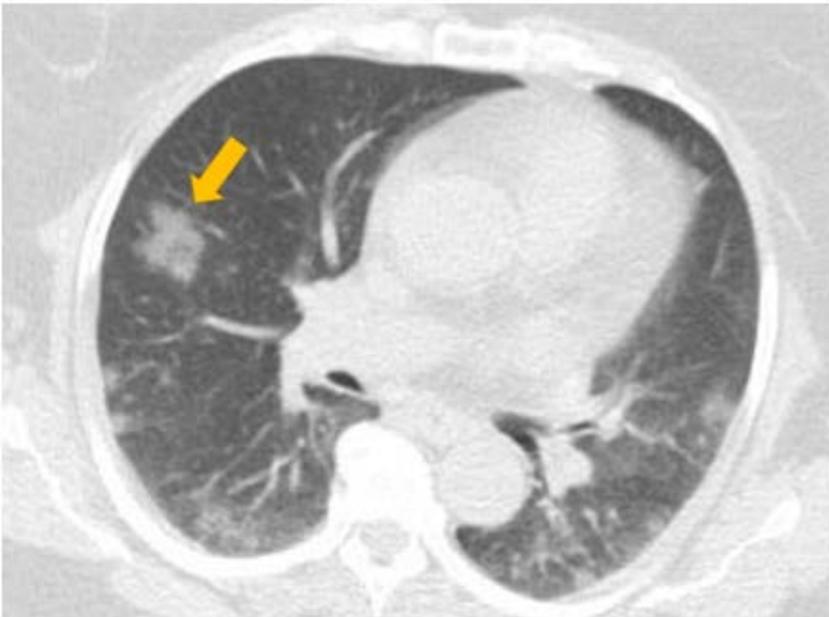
Ground-glass density in a 48-year-old female with COVID-19 patient presenting with fever and cough. Axial CT scan shows bilateral groundglass density (yellow arrow) in the middle and lower lobes.
